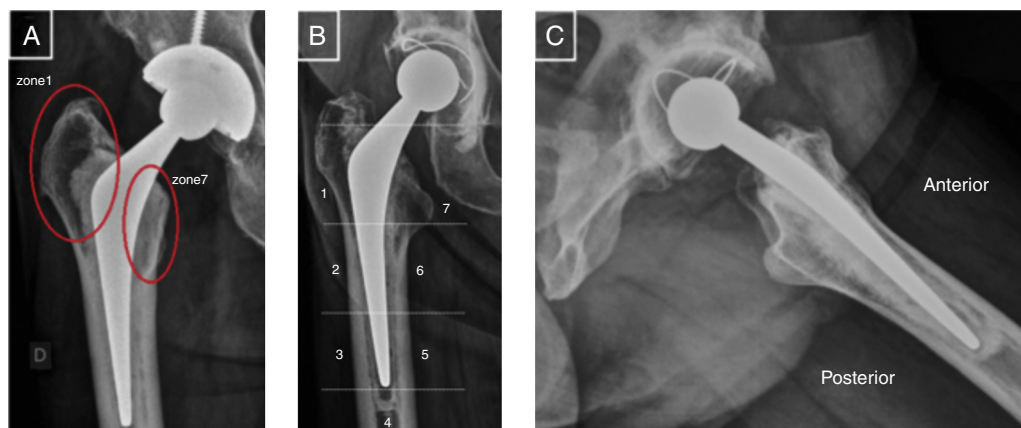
Decreased bone density in zone 1 and preservation in zone 7/calcar (A). Presence of radiolucency in zones 2, 3, 4, and 5, and presence of bubbles in zones 4, 5, and 6 (B). Lateral view radiograph disclosing the recurvatum stem positioning (C).
